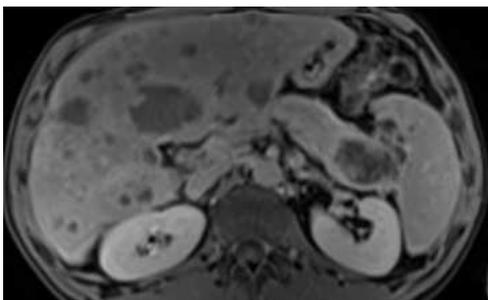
CE MRI of upper abdomen; Axial plane; Pancreatic tail neoplasm with infiltration of spleen and liver metastases.
